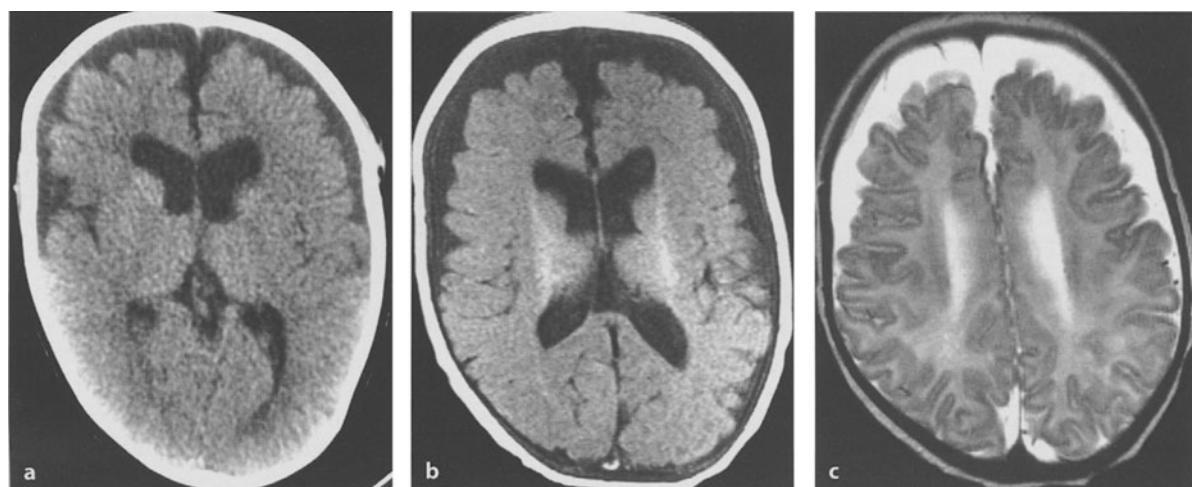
Benign pericerebral collections. a CT scan of a 4-month-old boy who presented with macrocephaly and seizures. Enlarged subarachnoid spaces are seen in the frontal regions. The anterior interhemispheric and right sylvian fissures are splayed open. Mild ventriculomegaly is present. b T1-weighted MRI scan, showing signal intensity in the pericerebral collections similar to ventricular CSF. The fluid of the collections "enters" the sulci, splaying them open. c T2-weighted MRI scan, showing clear signal voids from cortical veins, traversing the collections from the dura to the surface of the brain
